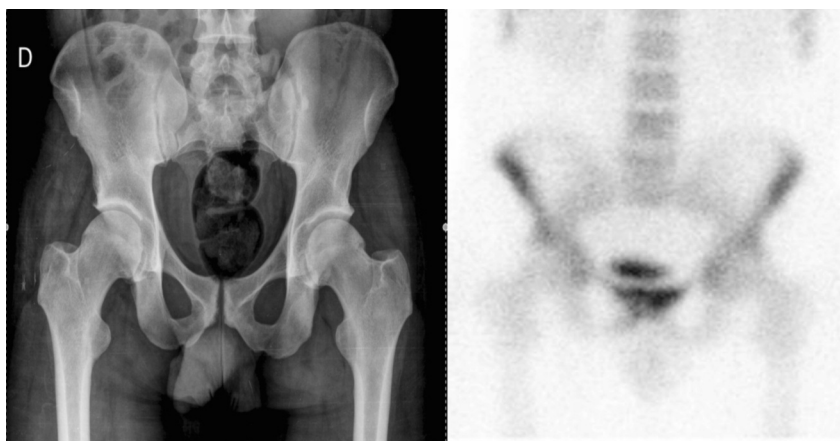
Plain X-ray of the pelvis (left) showing discrete subchondral sclerosis; and technetium and gallium scintigraphy scan (right) showing hypercapture in the pubic symphysis.
